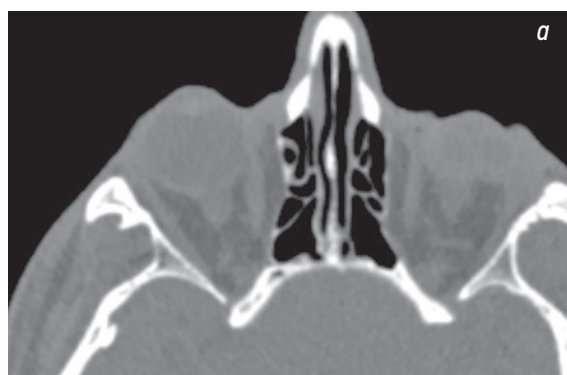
Multispiral computed tomography before surgery: *a* — axial sections; *b* — sagittal sections. Socket deformity . Increased socket volume. Posttraumatic eyeball subatrophy
